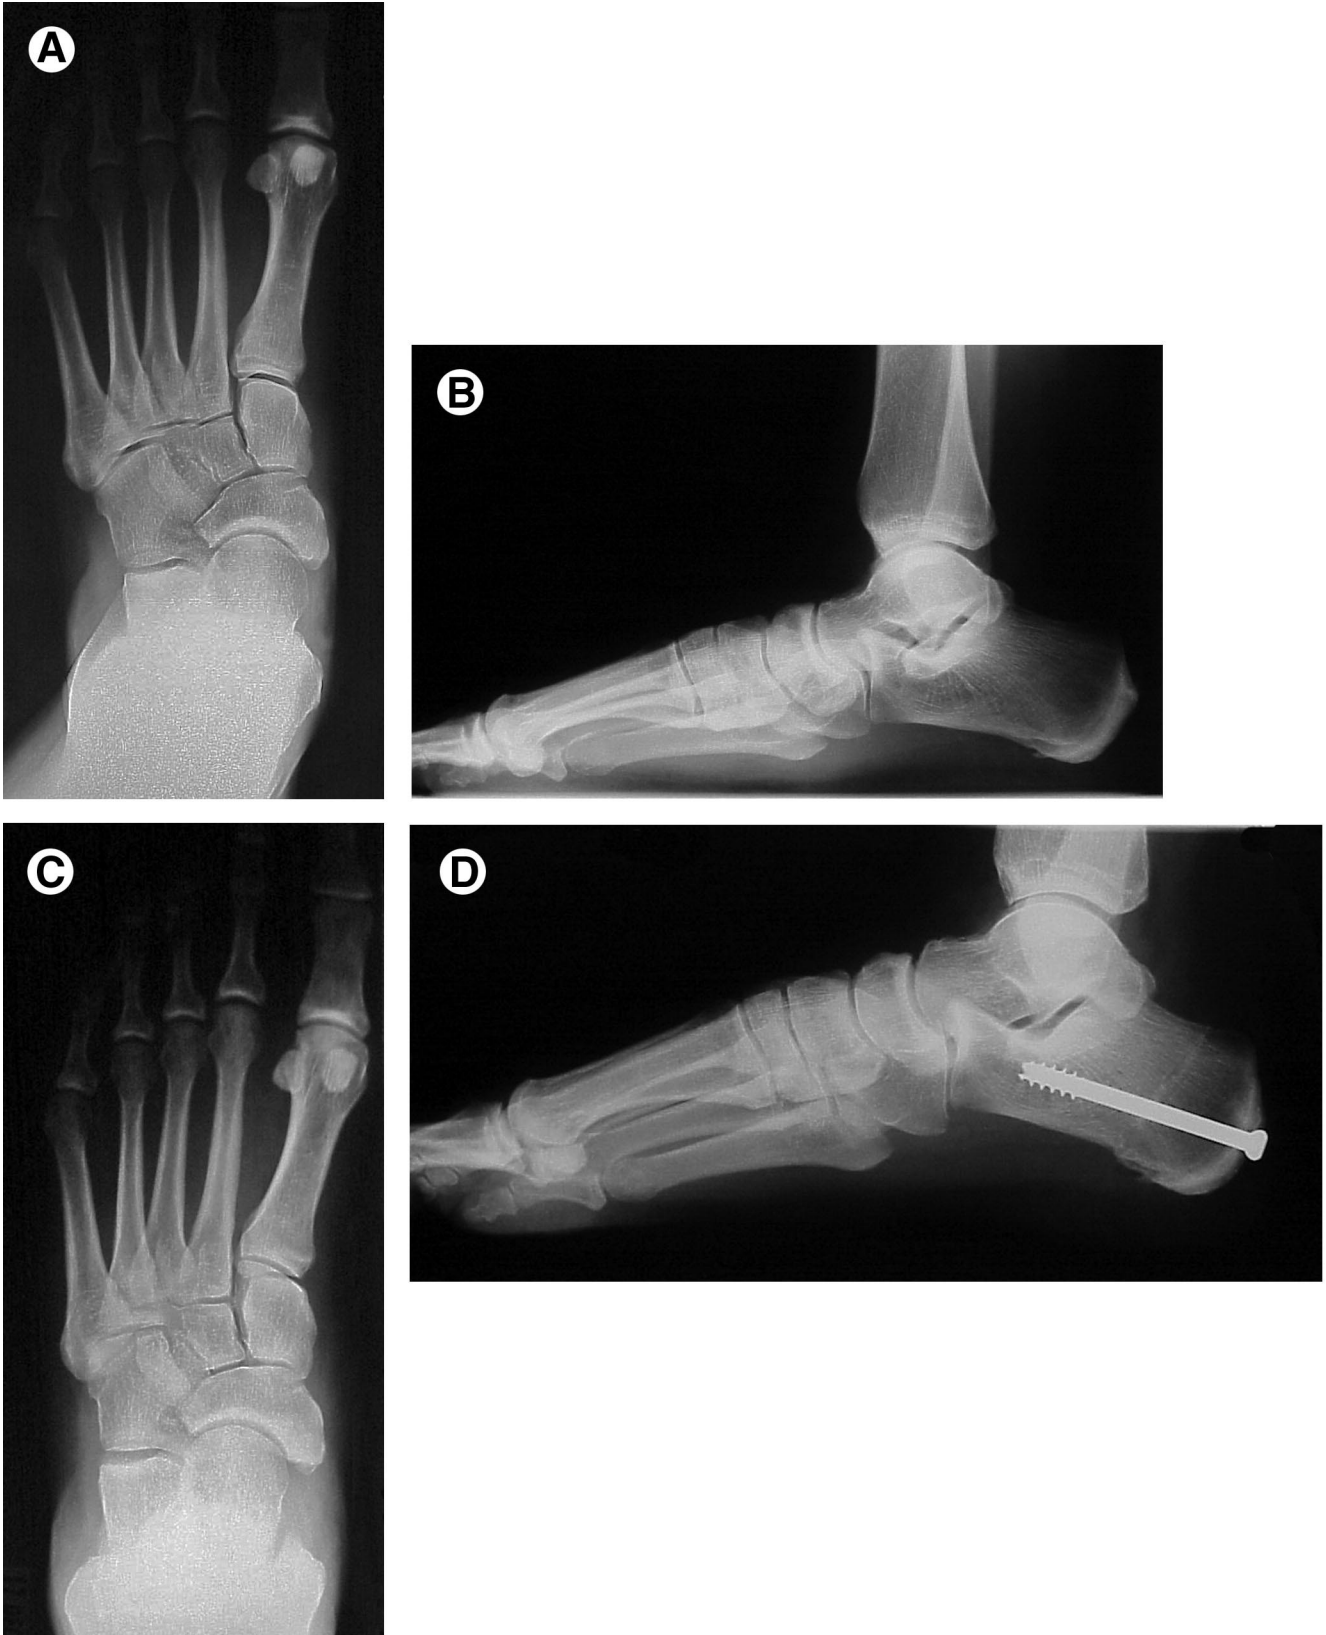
The posterior calcaneal osteotomy involves medial displacement of the posterior fragment to place the leg axis through the foot. Preoperative weightbearing (A) AP and (B) lateral radiographs show a flatfoot deformity with low calcaneal inclination or pitch and depression of the medial longitudinal arch. Forefoot abduction is limited. Postoperative weightbearing (C) AP and (D) lateral radiographs show a posterior calcaneal osteotomy with medial displacement. Improvement of talocalcaneal relationships can be appreciated as well as improved calcaneal inclination and arch height.
